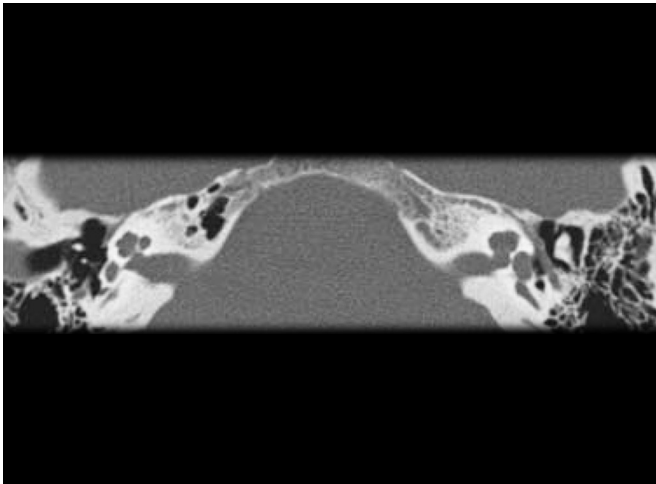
Computed tomography (CT) scan (axial section) of the temporal bones. The left cochlea is shorter and has a deficient modiolus. The normal right cochlea is shown for comparison. *Source:* Adapted with permission from Karlberg et al.²¹
